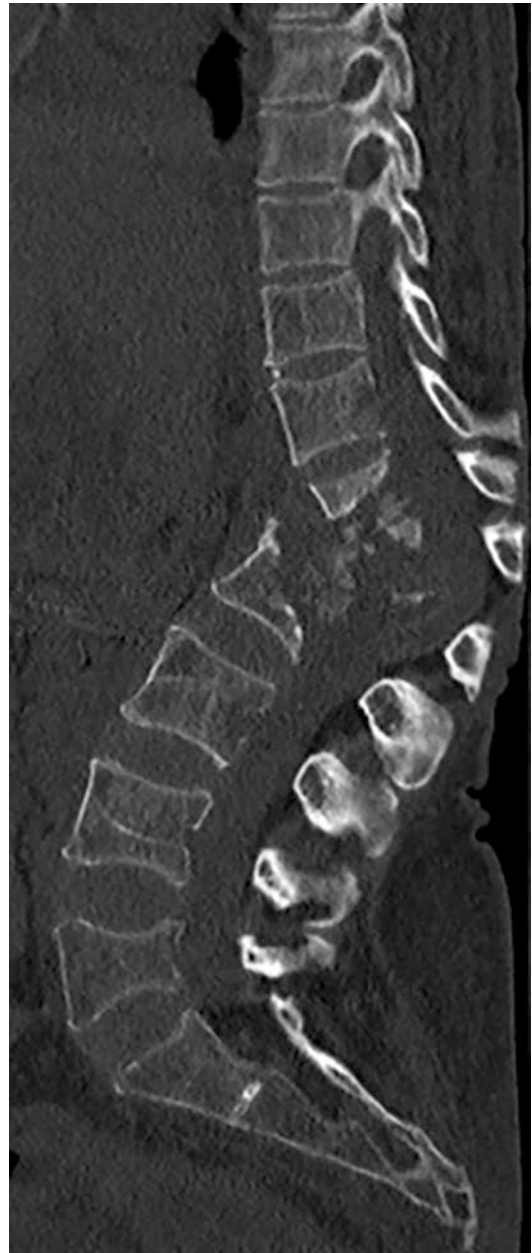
Spinal tuberculosis. Sagittal CT of the thoracolumbar spine demonstrates osseous destructive changes with resulting kyphotic deformity secondary to tuberculosis infection in the spine
